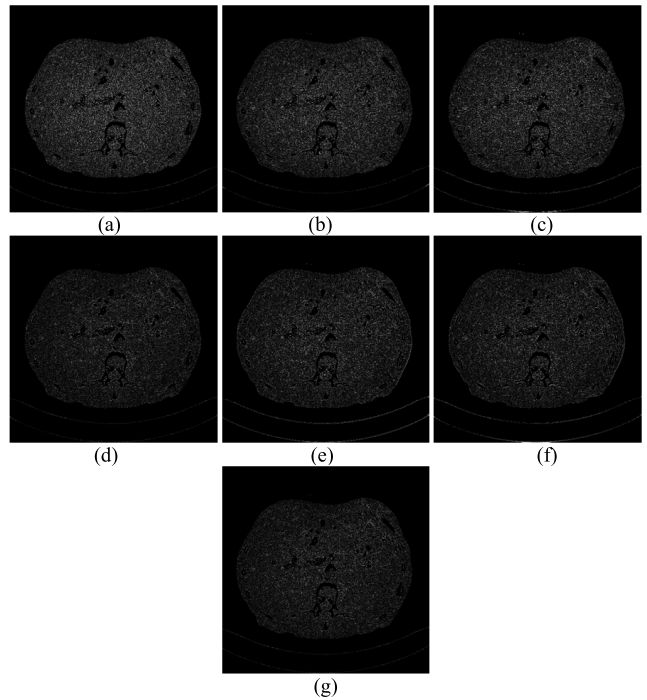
Absolute difference image relative to the corresponding normal-dose CT image in Fig. 3. (a) low-dose, (b) NLM, (c) BM3D, (d) RED-CNN, (e) WGAN-VGG, (f) SMGAN, (g) Proposed.
